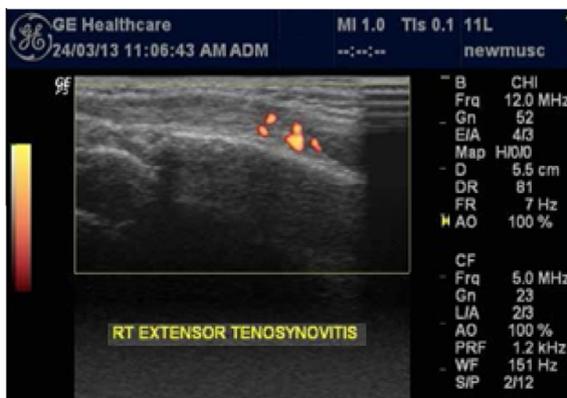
Ultrasonographic image (longitudinal section) showing inflammatory tenosynovitis of the extensor tendons in a patient with RA (left) and sclerosing tenosynovitis in a patient with SSc (right).
